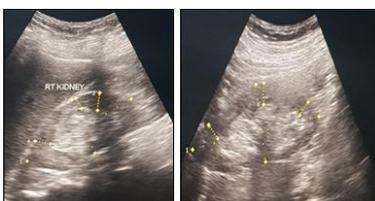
CASE, sonographic CKD score calculation
